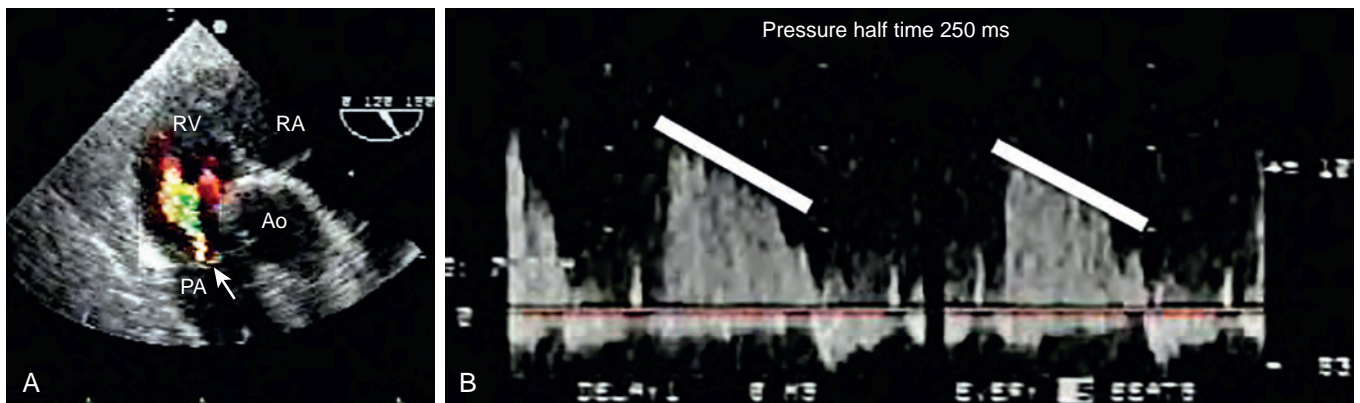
Pulmonary insufficiency. Transgastric imaging shows right ventricular inflow and outflow. (A) Color Doppler applied to the pulmonary valve shows regurgitation as supported by (B) the pressure half time of 250 ms. Ao, Aorta; PA, pulmonary artery; RA, right atrium; RV, right ventricle.
